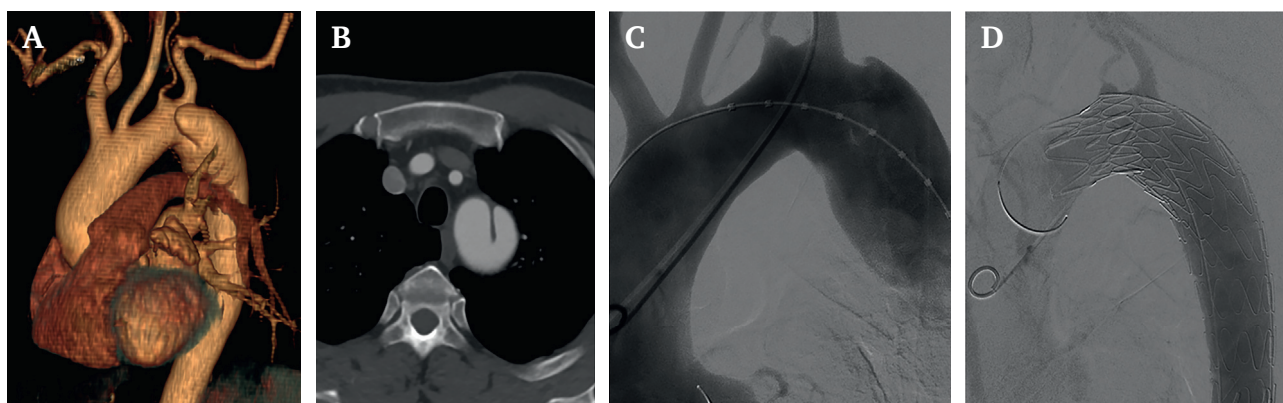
A, B. Pre-operative computed tomography angiography showing an aortic arch dissection aneurysm with an isolated left vertebral artery (ILVA), which arose from the top of the aortic arch with a diverticular orifice. C. Intra-operative angiography confirmed the aortic arch dissection aneurysm with an ILVA. D. A covered stent graft was deployed in the aortic arch covering the primary tear of the dissection, ILVA, and left subclavian artery.
